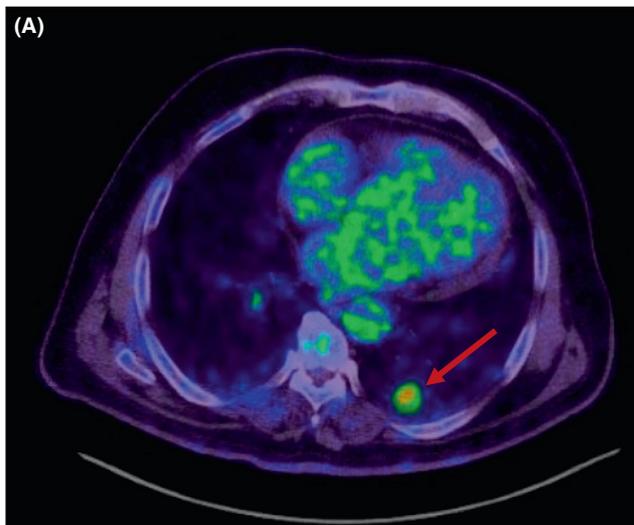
(A) FDG-PET showed abnormal accumulation in multiple nodules including left lower lobe nodule (arrow). CT-guided biopsy was performed from this nodule. (B) FDG-PET showing abnormal accumulation in the right lung pulmonary nodule (arrow).
